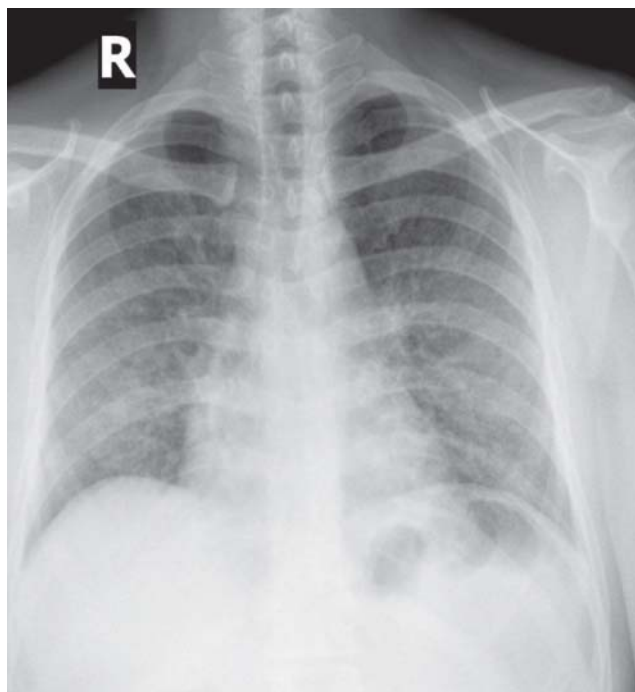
Chest radiograph (postero-anterior view) showing bilateral reticulonodular opacities.
